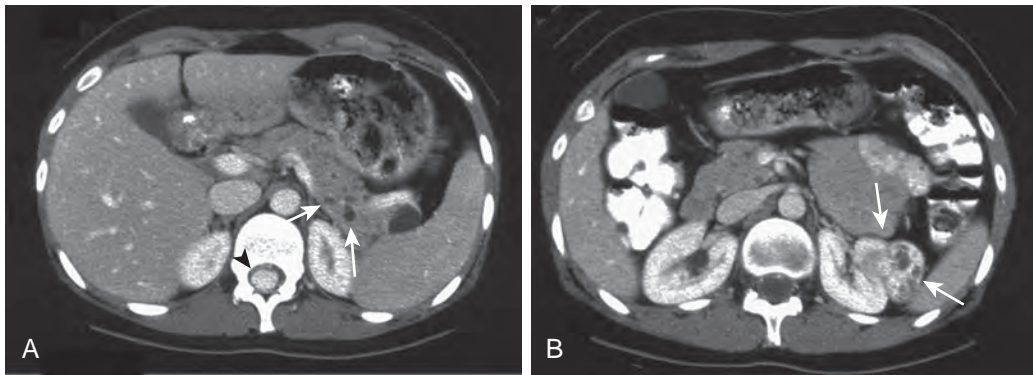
von Hippel–Lindau disease. A. CT scan through the pancreas demonstrates small cysts within the tail of the pancreas (arrows) in a young woman with von Hippel–Lindau disease. A hyperenhancing mass within the spinal canal is consistent with a hemangioblastoma (arrowhead). B. CT scan through the level of the kidneys demonstrates a heterogeneous mass within the left kidney consistent with a renal cell carcinoma (arrows).
